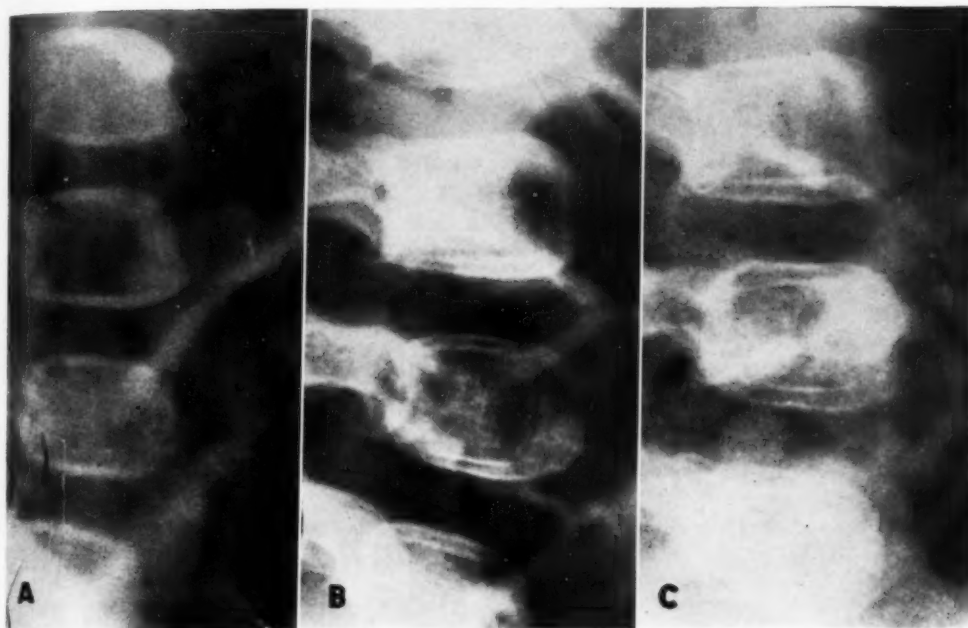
Development of transverse lines. Lateral views of the lumbar spine at one-year intervals after post-operative roentgen therapy for neuroblastoma in a seven-month-old infant. The calculated incidental dose to the body of L-2 was 1,360 r in eleven days and, two months later, 626 r in five days.
